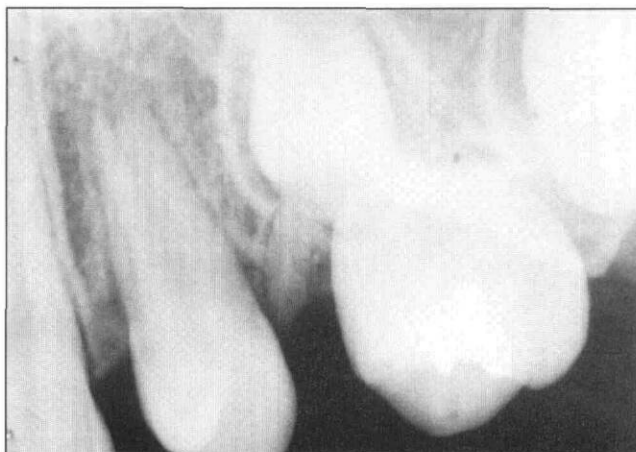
Periapical radiographs showing absence of roots on the maxillary left first molar and second premolar. A retained primary tooth root was also present between the first premolar and first molar.
